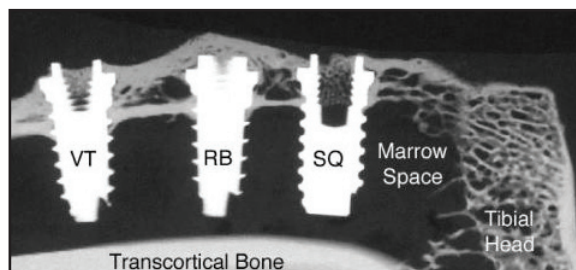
Radiographic bone density. VT: V-thread; RB: reverse buttress thread; and SQ: square thread. No significant differences were found in the radiographic density results.
